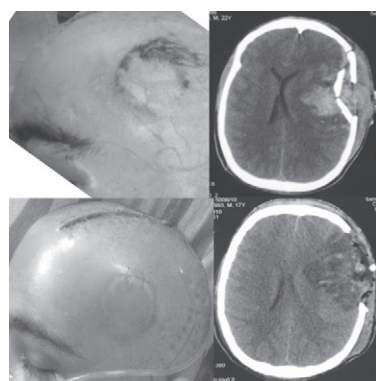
Pre- and post-operative clinical photo and CT brain in a patient of non-metallic missile (tear-gas shell) injury showing 5 cm x 5 cm circular scalp tear in the left fronto-parietal region overlying fracture, dural tear, brain laceration and contusion.
